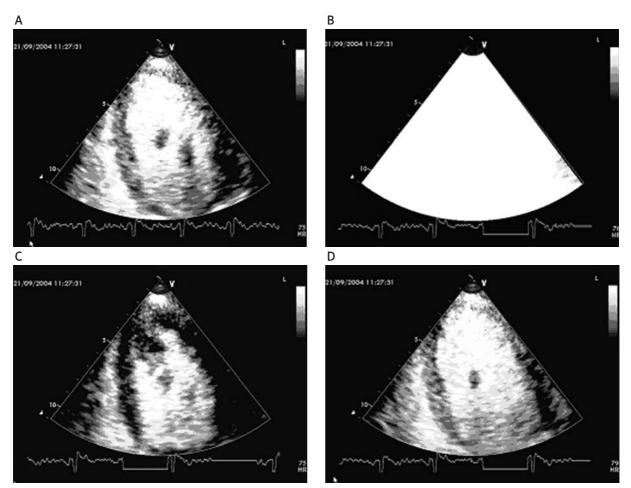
Real time contrast echocardiograms, four chamber view, 60-year old patient 2 days after anterior wall acute MI with normal perfusion in the infarct area. A. Complete LV opacification after a bolus of 0.3 ml Optison. B. Ultrasound beam of high Mechanical Index – flash. C. Imaging directly after flash: complete contrasting of LV, all bubbles in myocardium destroyed. D. Imaging after a few heart cycles later: complete contrasting of interventricular septum and LV apex
